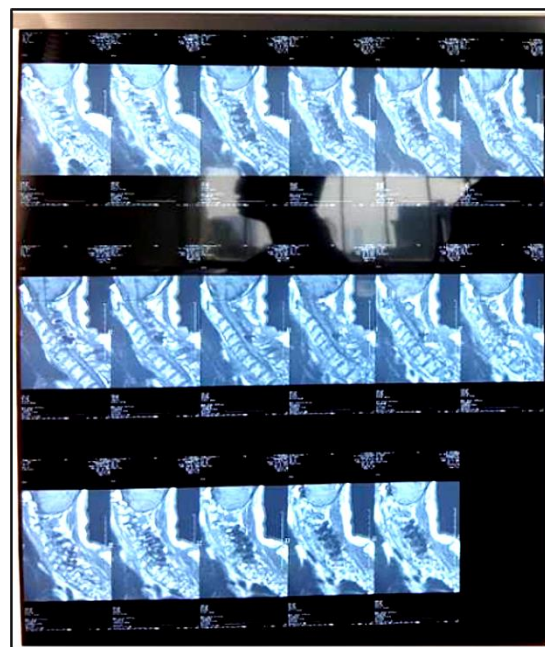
Cervical MRI showing disc bulging and canal stenosis from C3 to C7 with reduced spinal cord myelopathy
